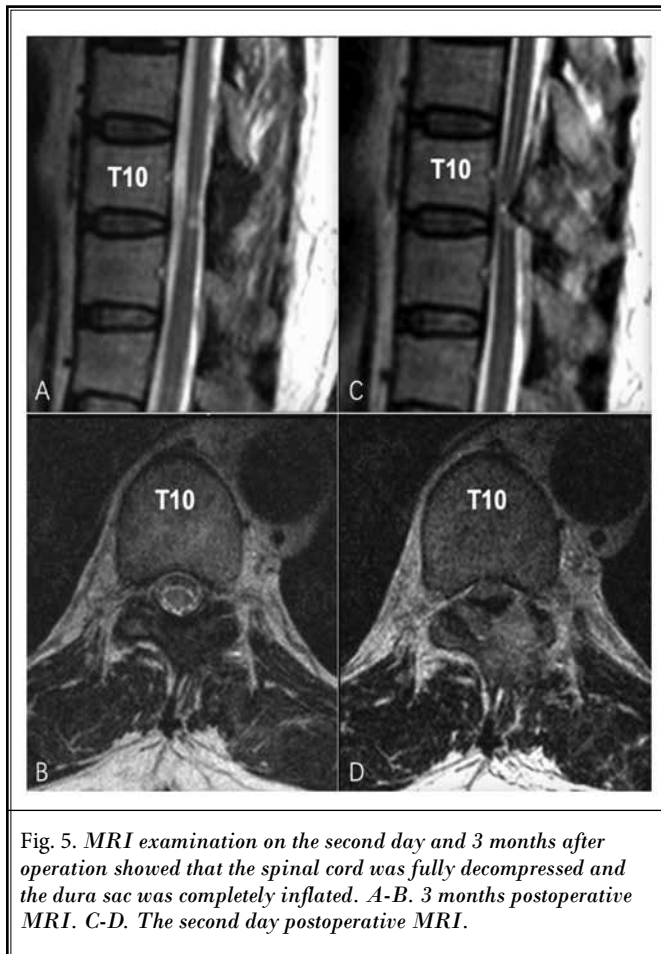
MRI examination on the second day and 3 months after operation showed that the spinal cord was fully decompressed and the dura sac was completely inflated. A-B. 3 months postoperative MRI. C-D. The second day postoperative MRI.
